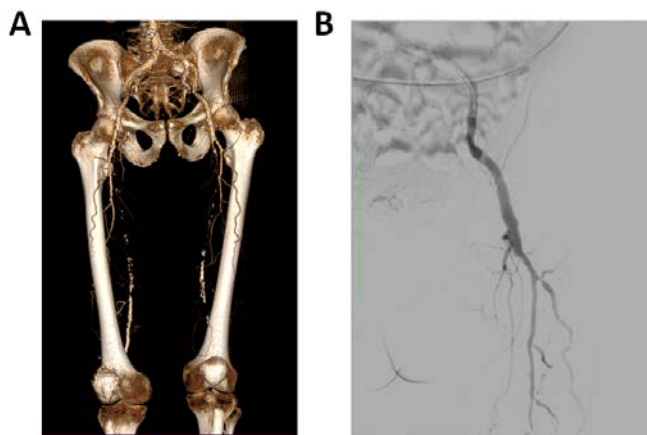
An example case of superficial femoral artery (SFA) occlusion from the ostium. A. Multi-spiral computed tomography of the lower limb arteries with intravenous contrast: bilateral SFA occlusion and left-sided popliteal artery occlusion; B. The angiography of SFA occlusion left from the ostium.
